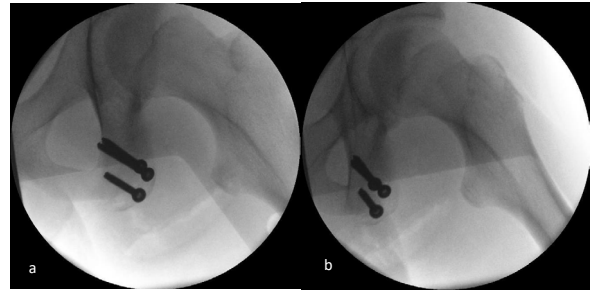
(a, b) – Postero-anterior (a) and alar oblique view radiographs of the right hip (b)
